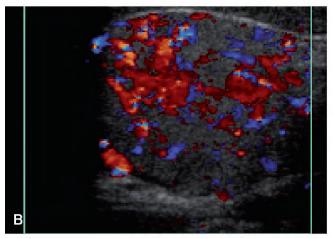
Ultrasound of lymph node metastasis from follicular variant of papillary thyroid carcinoma: right segment 4. A, Transverse diameter: 27 mm. B, Color Doppler, Transverse.
